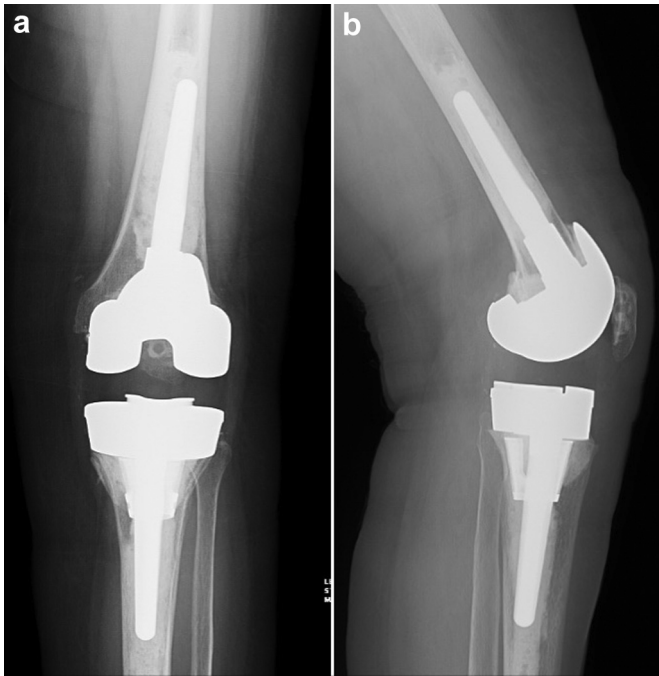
AP (a) and lateral (b) radiographs following second stage reimplantation of her left total knee arthroplasty.
